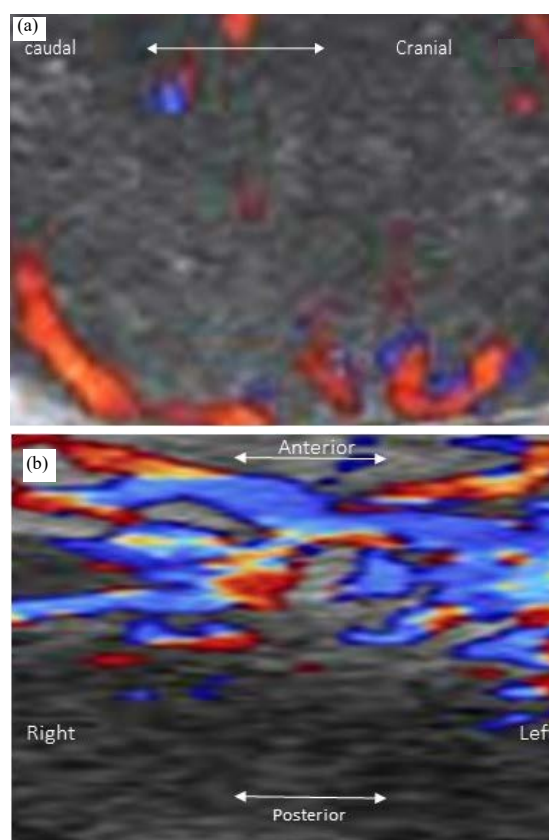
(a-b): (a) A color Doppler sonogram of a 28-year-old man presented with foot mycetoma confirmed as eumycetoma. The color Doppler sonogram was a longitudinal section of infected area with eumycetoma at the dorsum of the right foot reveals hypervascularity and (b) A color Doppler sonogram of a 30-year-old man presented with foot mycetoma confirmed as actinomycetoma. The Doppler sonogram was a transverse section taken at infected area with actinomycetoma at the dorsum of the right foot reveals moderate vascularity
